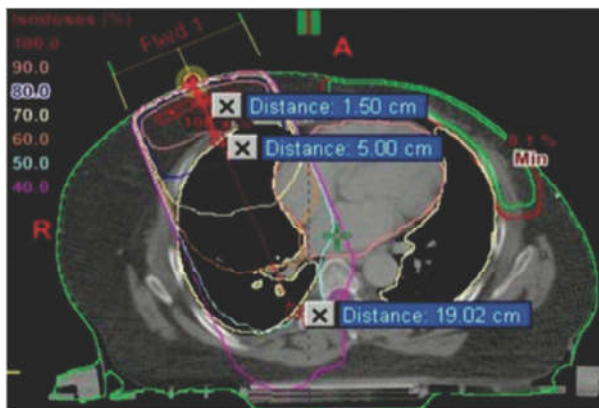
Isodose curves at different depths in CT slice of patient
